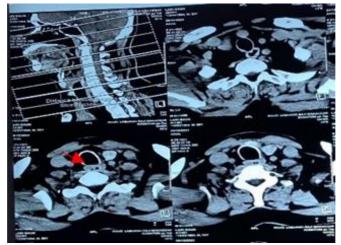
CT scan of the neck without contrast, axial reformat coronal and sagittal sections. The image depicts a glottic tumor (red arrow) involving the vocal cord, classified as stage T3N2cMx.
